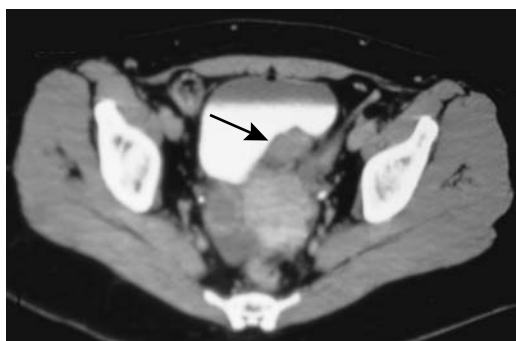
Bladder endometriosis. Computed tomography identifies an irregular intramural tumor posterior and to the left of the bladder (arrow). The appearance mimics a neoplasm. (Courtesy of Patrick Fultz, M.D., University of Rochester.)
